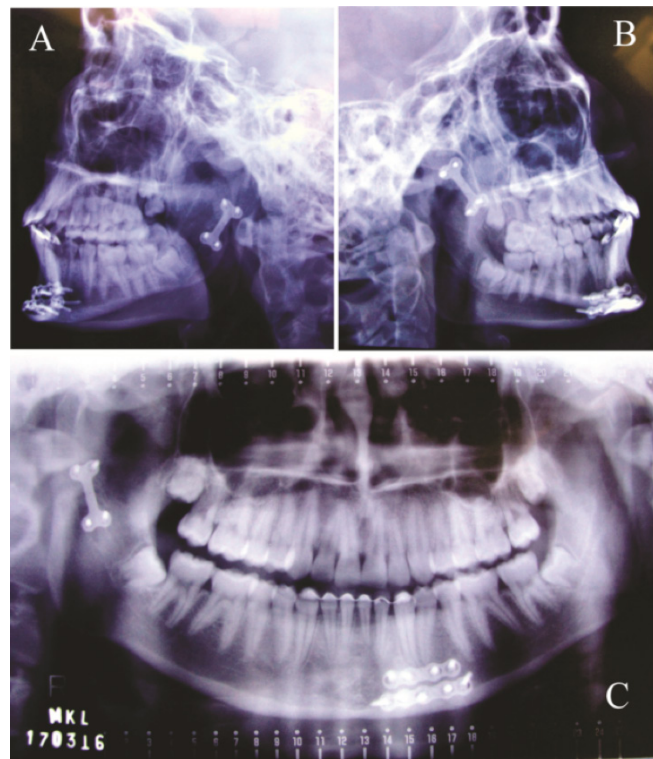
Radiographic examinations assuring good reduction and fixation of fractures
